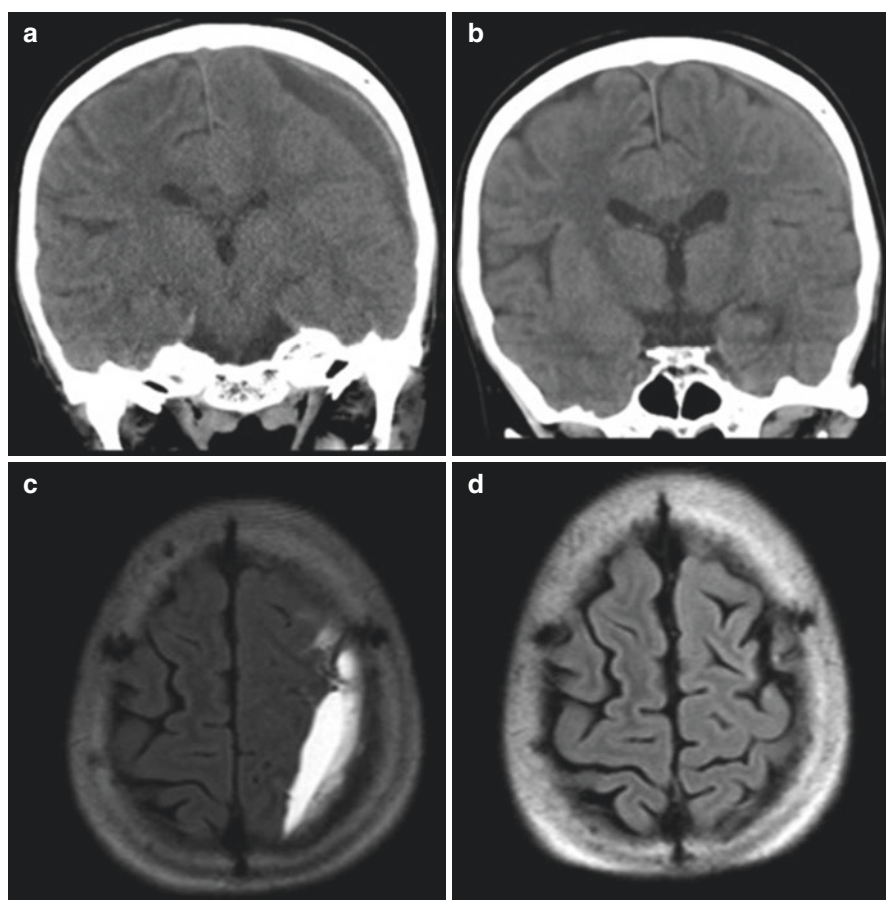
Incidentally detected left-sided CSDH of a patient with aplastic anemia who has no clinical symptoms. Coronal NECT sections (a) and axial MRI sections (c) revealed the presence of CSDH. At a follow-up of 2 months, coronal sections on NECT (b) and axial MRI sections (d) showed regression of the hematoma
